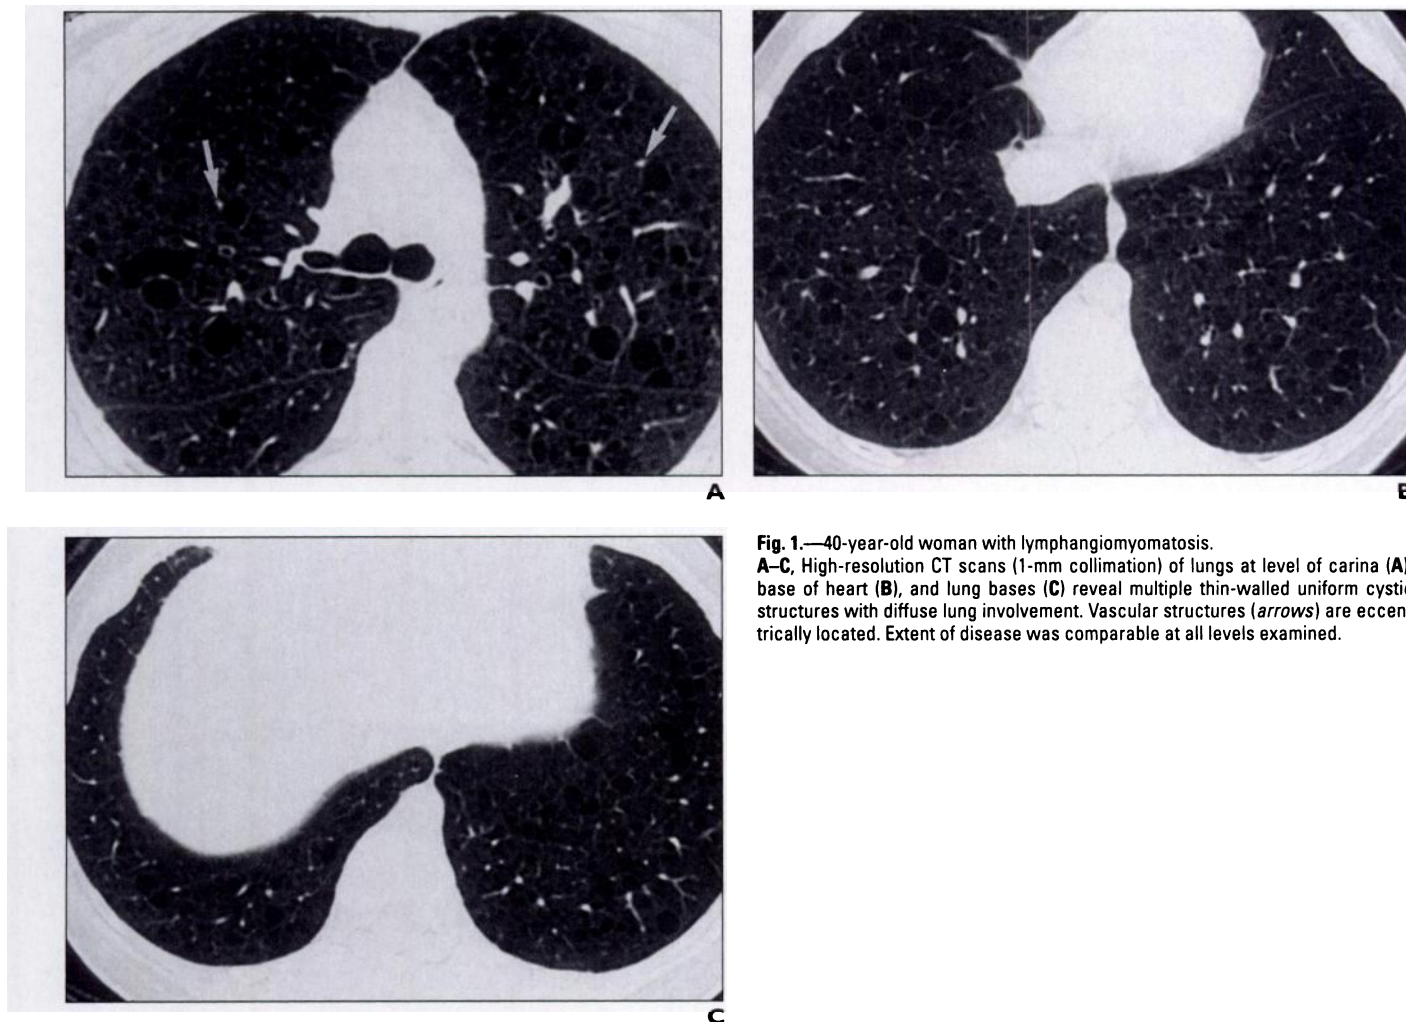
40-year-old woman with lymphangiomyomatosis. A–C. High-resolution CT scans (1-mm collimation) of lungs at level of carina (A), base of heart (B), and lung bases (C) reveal multiple thin-walled uniform cystic structures with diffuse lung involvement. Vascular structures (arrows) are eccentrically located. Extent of disease was comparable at all levels examined.
